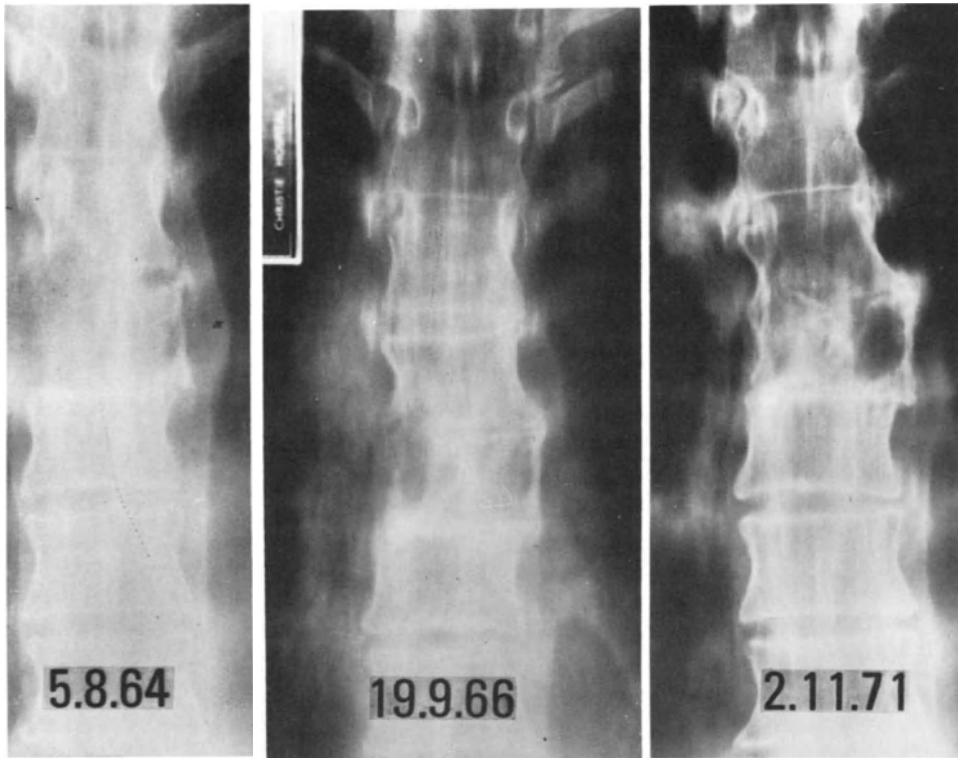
Spinal metastasis with paraplegia. Full recovery with decompression laminectomy, ¹³¹I therapy, and X-ray therapy
